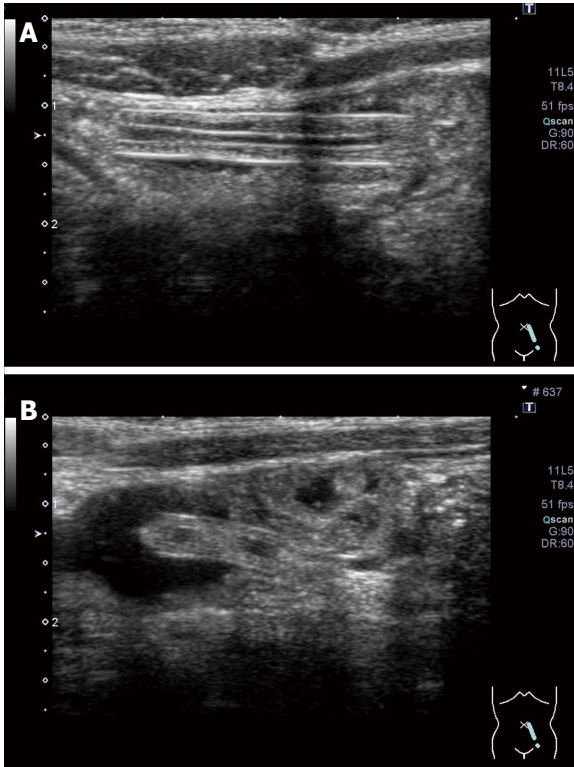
Abdominal ultrasound examination on the day after admission. The tubular structure in the patient's small intestine was still observed. An ultrasound examination shows a space between the intestinal wall and the tubular structure, and fluid could pass through this space.
